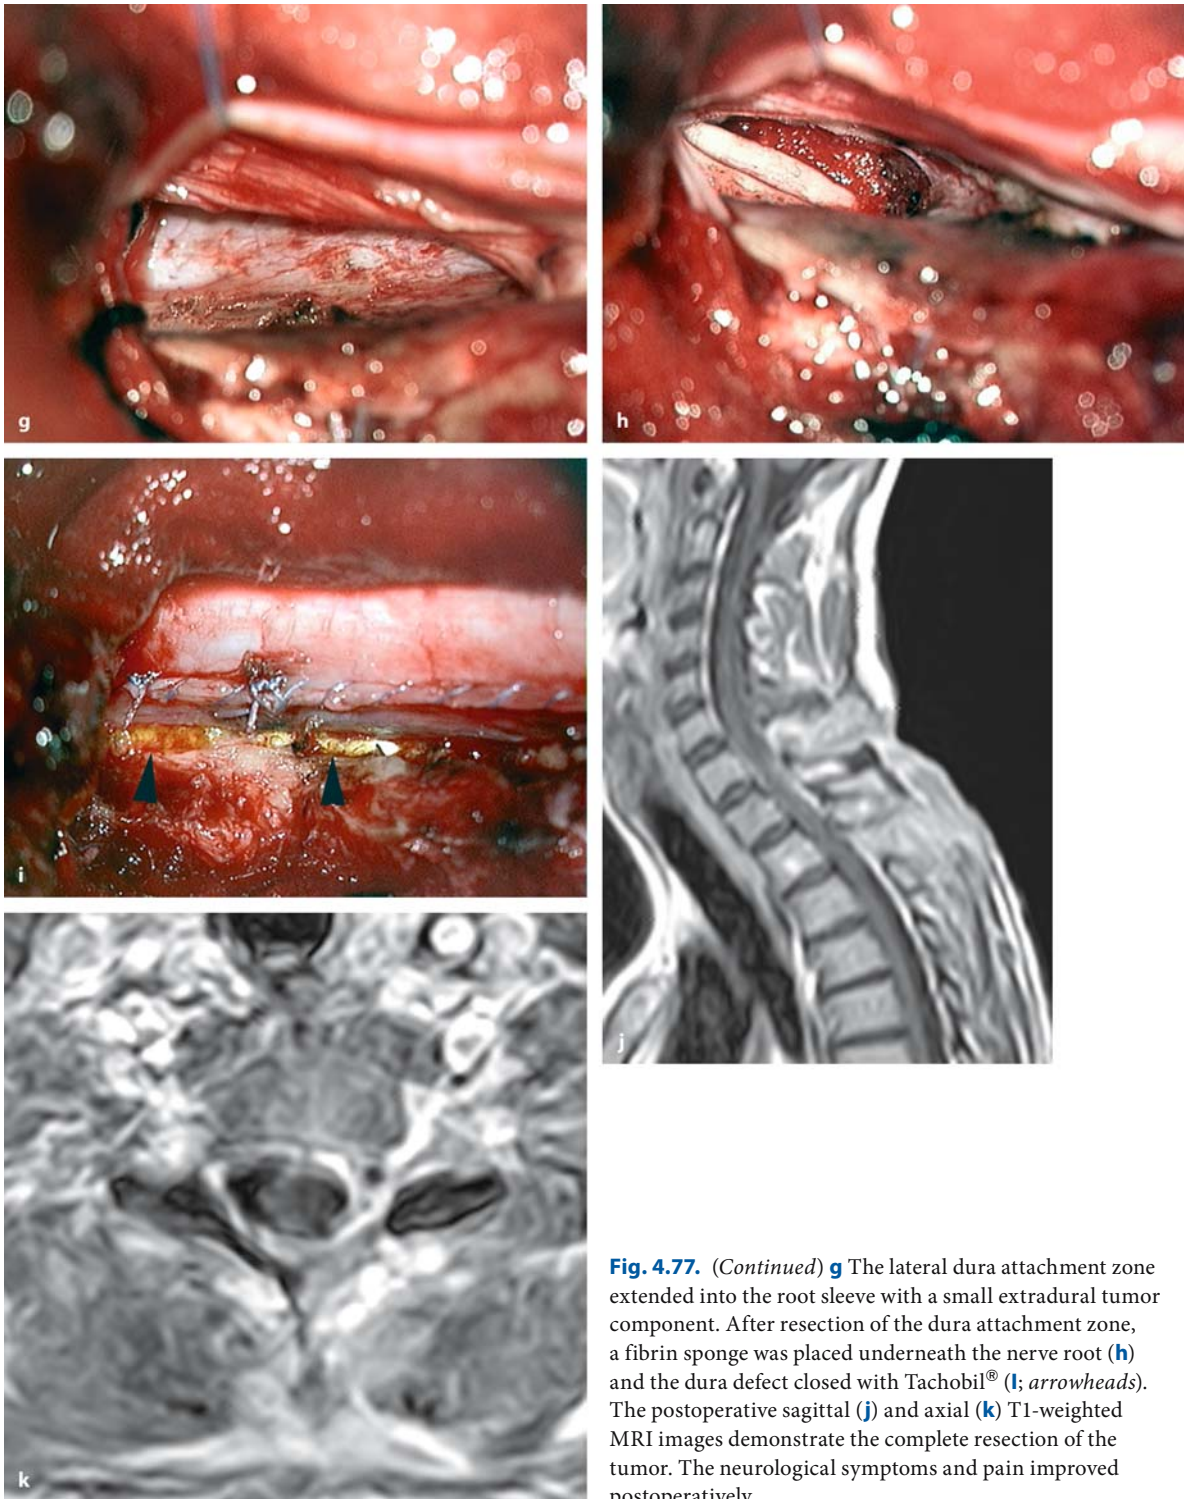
Sagittal (a) and axial (b) T1 weighted, contrast-enhanced MRI images of a meningioma at C7–Th1 on the left side in a 41-year-old woman with a 6-month history of pain and a slight gait ataxia. c This intraoperative view after
